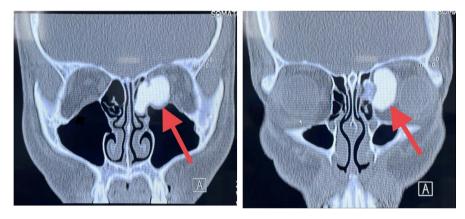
Coronal views of CT paranasal sinus showing a lesion extending from left ethmoid sinus into left orbital cavity (red arrow).
